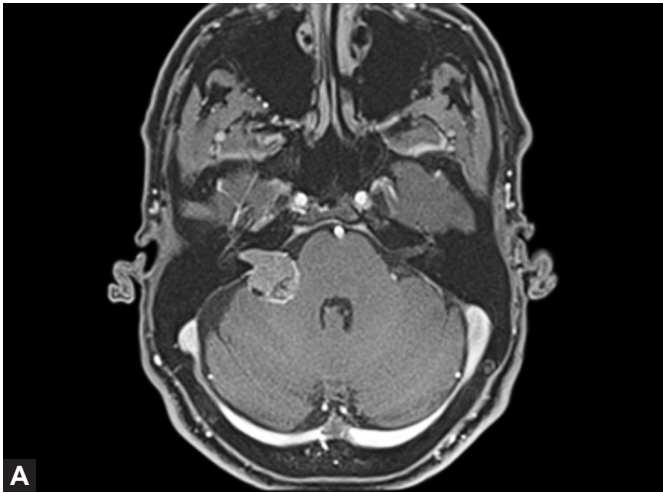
Small vestibular schwannoma. Axial Gd-enhanced T1 MRI sequence shows a small left-sided vestibular schwannoma with both a cisternal and intracanalicular component.
